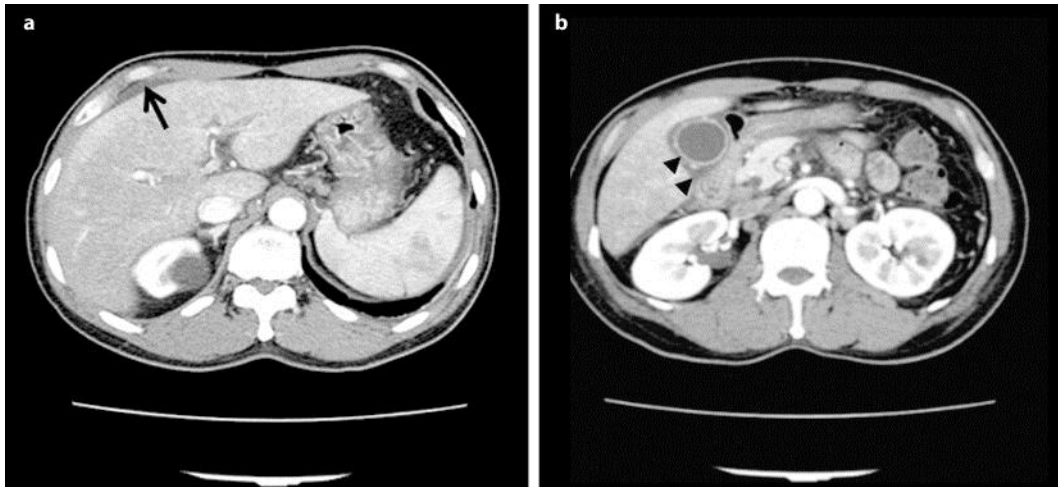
Computed tomography on admission showed minimal ascites (arrow) and mild hepatosplenomegaly (a) with a thickened gall bladder wall (arrowheads) (b). These indicated severe liver injury.
